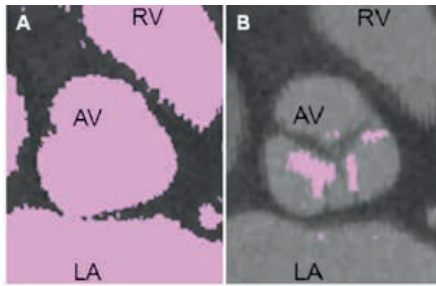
Aortic valve calcium assessed on contrast cardiac computed tomography angiography at the double oblique transverse view. A. Using a threshold of 130 HU detects all contrast, B. Using a threshold of 800 HU detects calcium on the aortic valve. AV=Aortic Valve, HU=Hounsfield Units, LA=Left Atrium, RV=Right Ventricle
